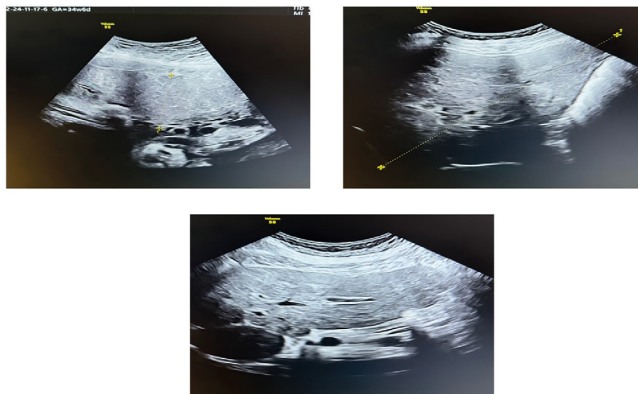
Liver Ultrasound: hepatic metastases (largest 69 mm in segments V-VIII), cirrhotic liver configuration, and signs of early portal hypertension
